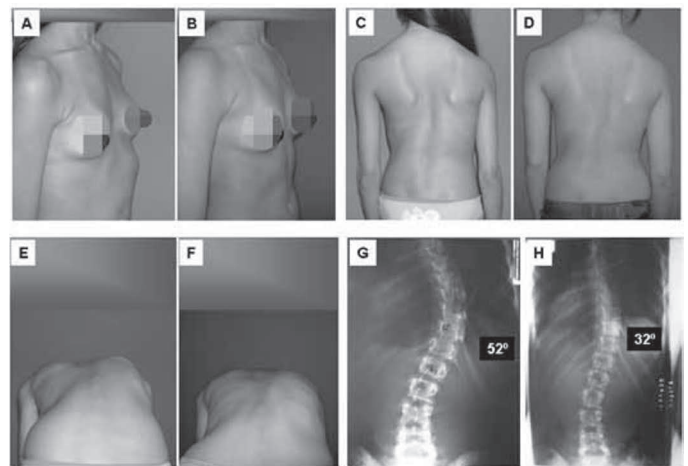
A 13-year-old female patient with 52° severe thoracolumbar dextroconvex scoliosis from T6 to L1, Risser 1 and discreet LPC in the anterior part of her chest, with moderate protrusions of the costal edges (A, C, E, G). She had received surgical indication due to the severity of the curve. Opted to first try concomitant treatment with DTC orthoses and brace shown in Figure 8. She regularly performed the DR method exercises in the DTC orthosis on a daily basis. She used the DTC orthoses about four hours a day and the brace about 19 hours a day. She received three new braces made by plaster mold over the course of treatment. Clinical improvement 33 months after starting treatment, shown in B, D, F, and radiographic evidence showing a reduction of the curve to 32°, shown in H, withdrew the indication for surgery.
